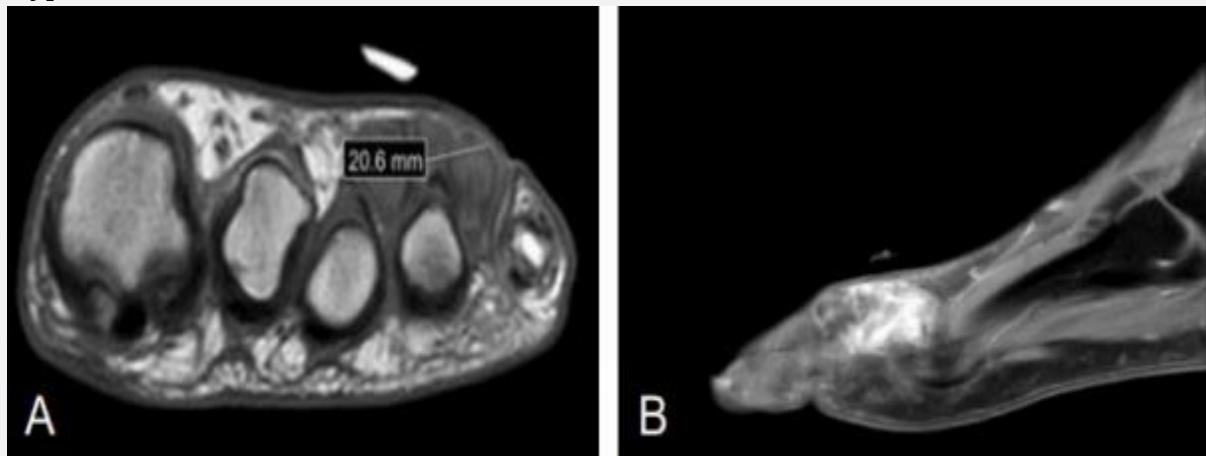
Soft tissue mass with several lobules at the left foot's PIPJ and distal fourth metatarsal. A) Images with T1 weighting show low intensity. B) Increased intensity and gadolinium enhancement on T2-weighted images in comparison to normal muscle.
